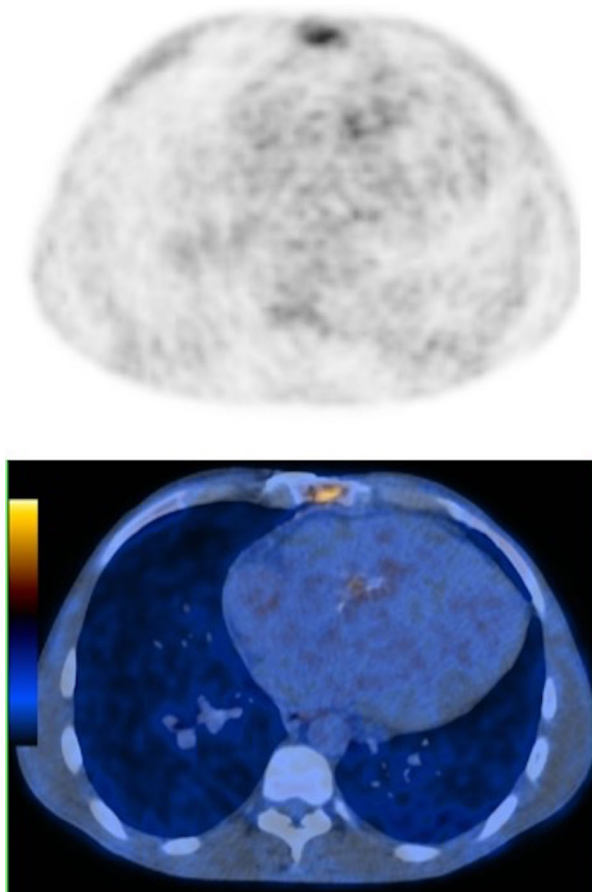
Maximum intensity projection of 18F fluoro-deoxyglucose positron emission tomography (18F-FDG-PET) and fusion with computed tomography (PET-CT), on axial view at level of sternum. 18F-FDG-PET (up) revealed maximal FDG uptake with maxSUV:3,8 on sternum, location confirmed on PET/CT fusion images (down). This FDG uptake was present in all sternum bone.
